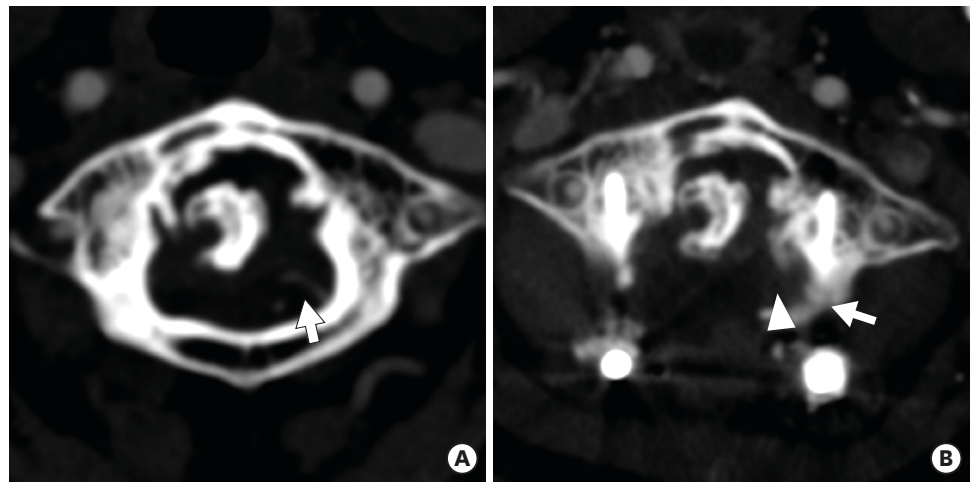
Comparisons between preoperative and postoperative images (day 4) of computed tomography angiography. (A) The left posterior inferior cerebellar artery begins between the C1-2 and progresses cephalad towards the cerebellum in the preoperative image (white arrow). (B) The left posterior inferior cerebellar artery may be injured or compressed by the left C1 lateral mass screw (white arrow), and the artery is not seen on the postoperative image (white arrowhead).
